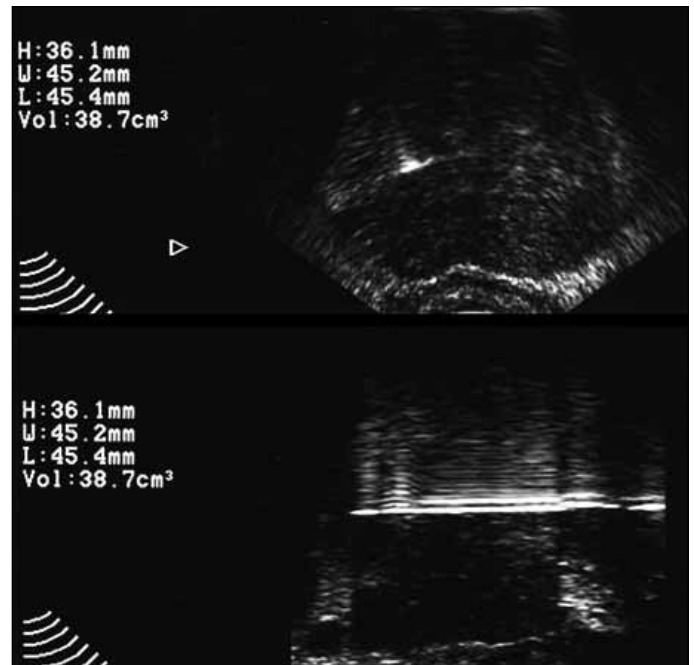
Axial and sagittal ultrasound view of seed placement for Patient no. 19.
